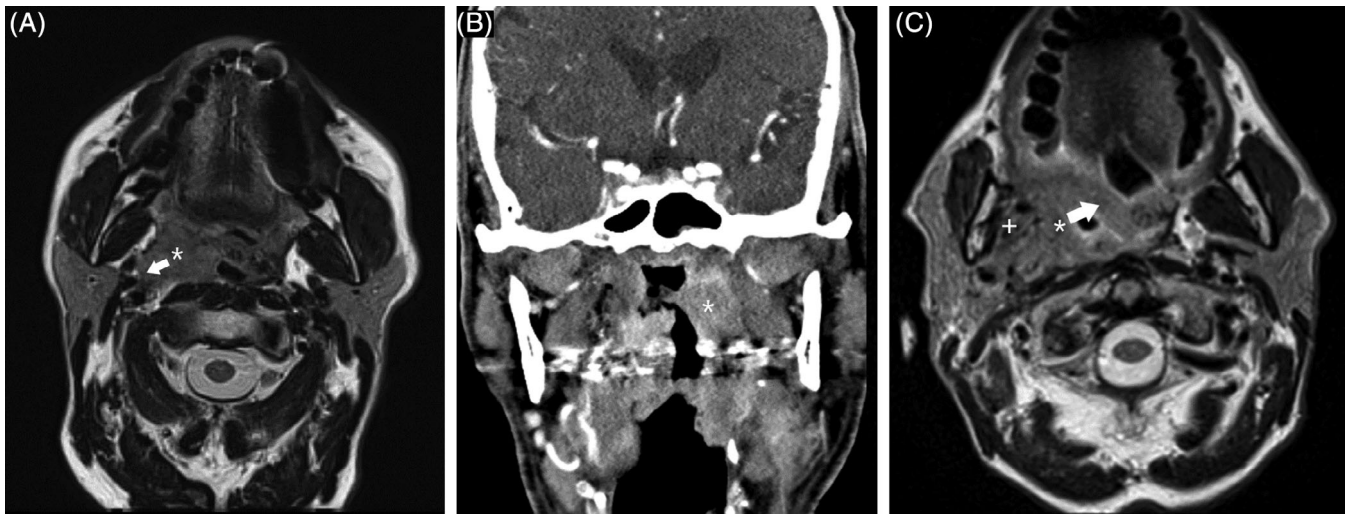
MR and CT images demonstrate examples of relative contraindications for tonsillar carcinoma in transoral robotic surgery (TORS). A, Axial T2-weighted MR image shows a right tonsillar carcinoma (*) with pre-styloid parapharyngeal fat involvement and extension laterally to abut the vascular structures (white arrow). B, Coronal contrast-enhanced CT shows a left-sided tonsillar carcinoma which extends superiorly to involve the nasopharynx (*). C, Axial T2-weighted MR image shows a right tonsillar mass (*) that has extended onto the right soft palate (white arrow). This is itself a relative contraindication but ultimately in this case, there is also right masticator space invasion (+) that was an absolute contraindication for TORS
